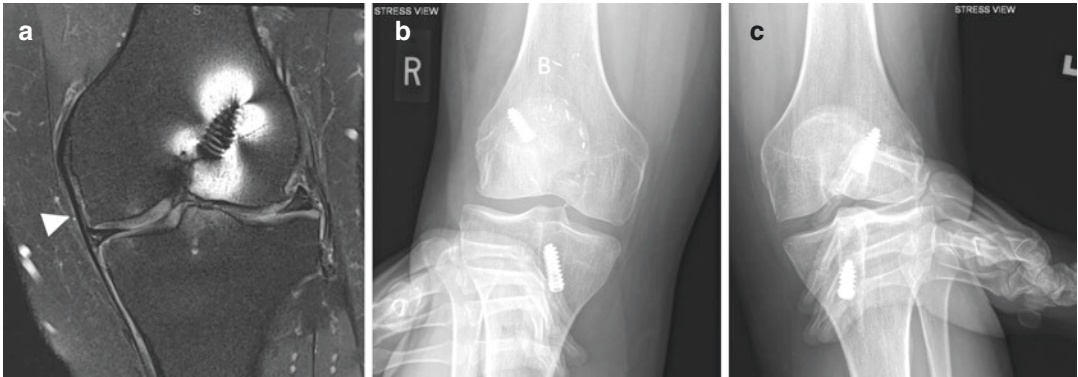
Stress radiographs indicating left knee medial collateral ligament laxity. This patient was a 38-year-old male who had undergone bilateral prior anterior cruciate ligament reconstructions and presented with recurrent left knee instability and laxity to valgus stress on exam. A left
